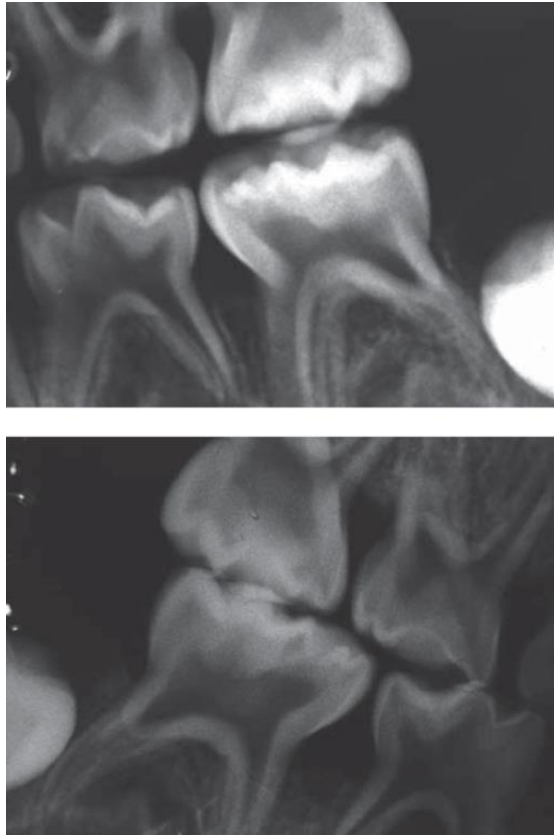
Horizontal bitewing of a 10-year-old XLH patient with evidence of enlarged pulp chamber and prominent pulp horns in both permanent and primary molars and (\*) shows Taurodontism of FPM (Duplan et al., 2021)
